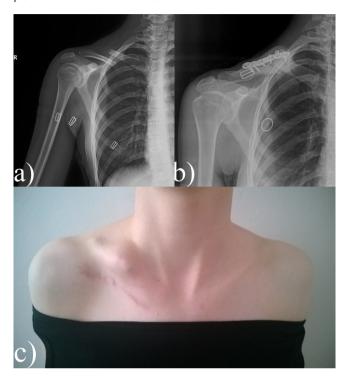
A patient with implant failure after surgical treatment of clavicle fracture: a) Pre-operative radiograph. b) Radiograph at post-operative month 16. c) Poor cosmetic result.
